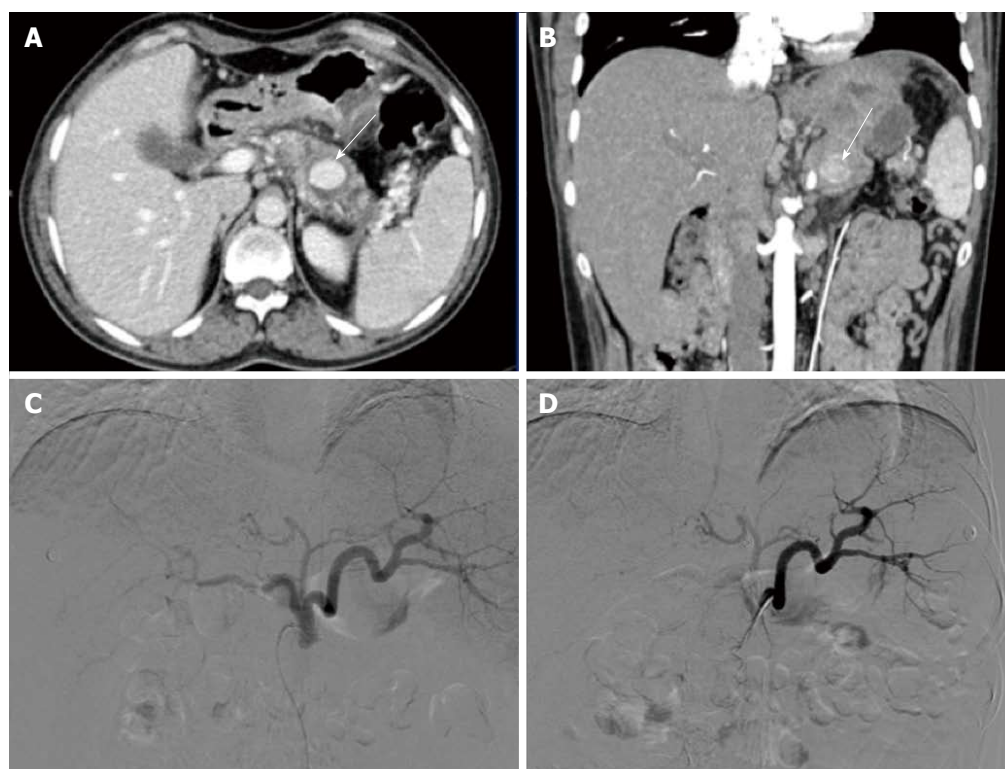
Pancreatitis related pseudoaneurysm (case 2). A: Axial contrast enhanced CT; B: Coronal maximum intensity projection CT images; C and D: Digital subtraction Images. In the background of pancreatitis there is a pseudoaneurysm in the distal body of the pancreas (arrow, A and B) which was not revealed on either left gastric artery (C) or splenic artery (D) angiograms. CT: Computed tomography.
